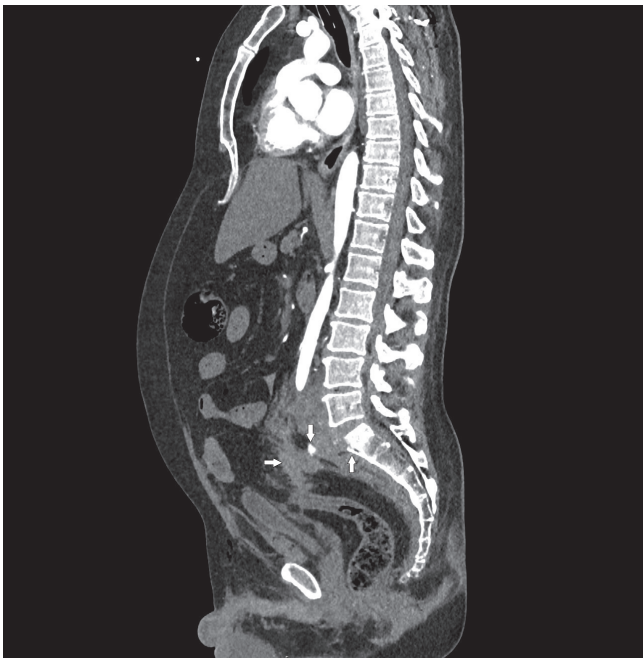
Sagittal CT scan revealed blood clots in the retroperitoneal space (left arrow); active bleeding to the site (middle arrow); and fracture of sacral promontory (right arrow).
